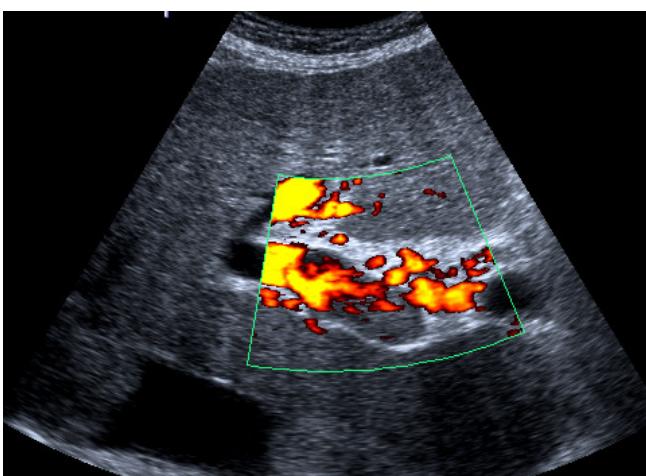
Acute portal vein thrombosis. Ultrasound of patient with acute PVT. (A) Hyperechoic material is located within the main portal vein. (B) Using the power mode for flow detection, blood flow is limited to those parts of the portal vein without hyperechoic material
